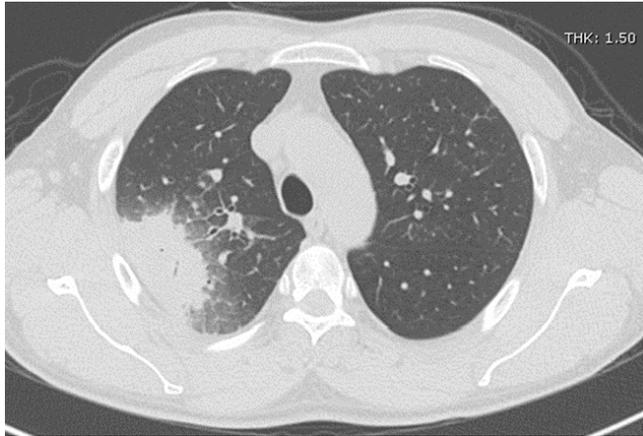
A 40-year-old male with underlying acute aplastic anemia and neutrophils 28 cells/mm³ presented with fever and cough. Axial thoracic CT scan demonstrated pulmonary consolidation surrounded with ground-glass opacity at right upper lobe that represented CT halo sign. The final diagnosis was invasive pulmonary aspergillosis.
